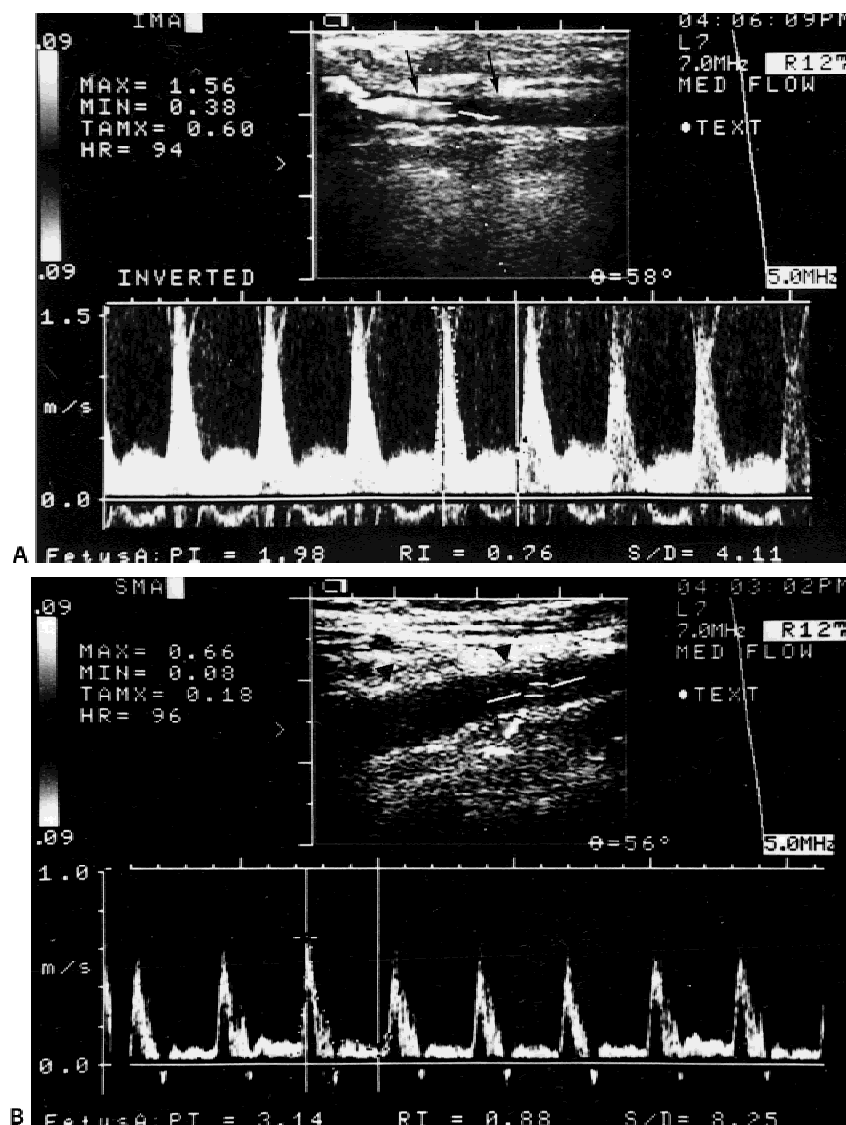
Twenty-nine-year-old woman with ulcerative colitis of the left colon. (A) Duplex sonogram of the inferior mesenteric artery (IMA) (arrows) in the active phase, before treatment. (B) Duplex sonogram of the superior mesenteric artery (SMA) (arrowheads) before treatment. (C) Duplex sonogram of the IMA (arrows) in the remission phase, after the start of treatment. (D) Duplex sonogram of the SMA (arrowheads) after the start of treatment. Note the significant changes in the spectral pattern and also decreases in the peak systolic velocity, end-diastolic velocity, and mean velocity in the IMA (arrows) in the remission phase of ulcerative colitis after the beginning of therapy in C. Note also the absence of change in the SMA (arrowheads) in B and D. AO and white arrows, aorta.
